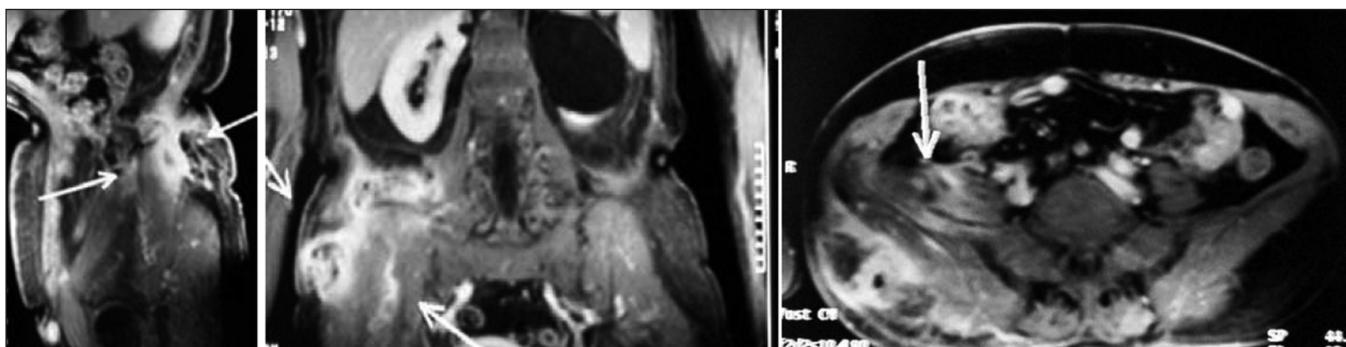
MRI of the retroperitoneal pseudomyxoma.
